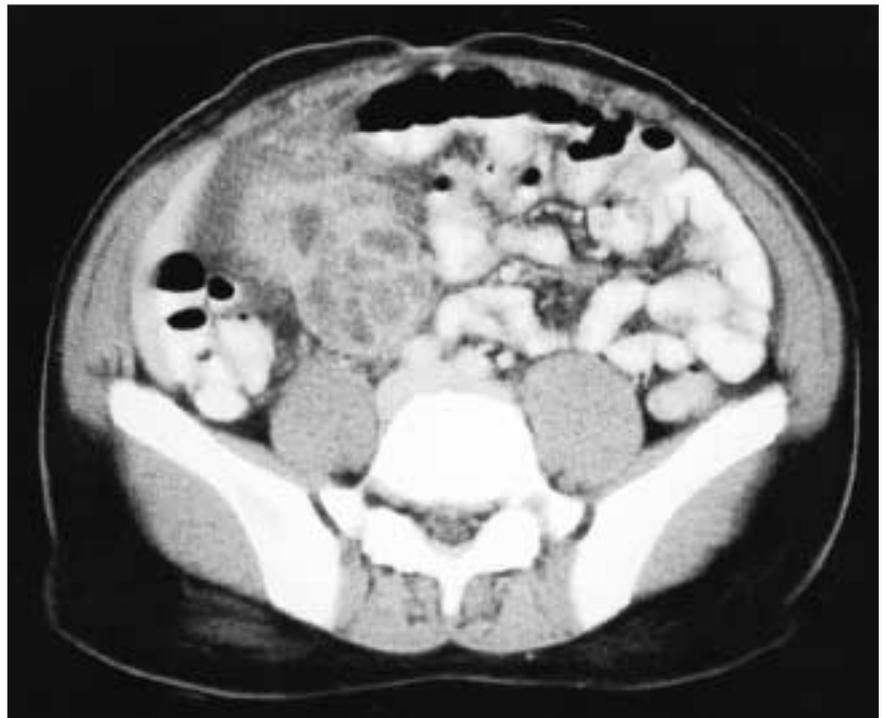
Abdominal computed tomography scan showing a large complex mesenteric mass in a 21-year-old man who had thalassemia major.
